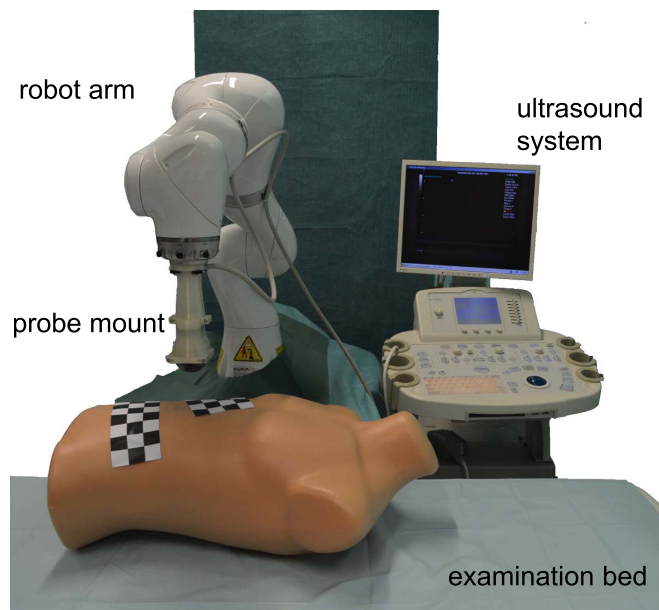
In the presented system setup, a RGBD-camera is mounted on the ceiling, observing the scene with the patient lying on the examination bed. The robotic arm is approaching the patient from above and is equipped with a curvilinear ultrasound probe.
